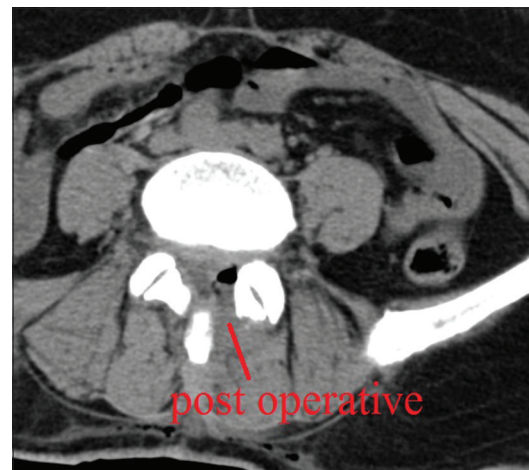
Postoperative computed tomography images of patient
